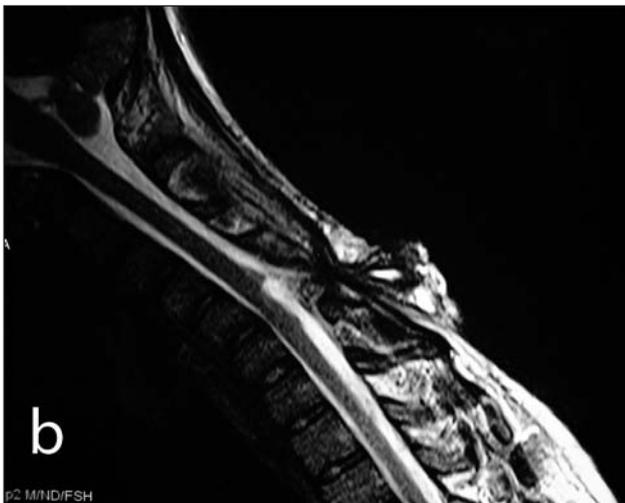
T2-weighted cervical MRI in hyperflexion. Cervical meningocele at the level of the C5 is seen
